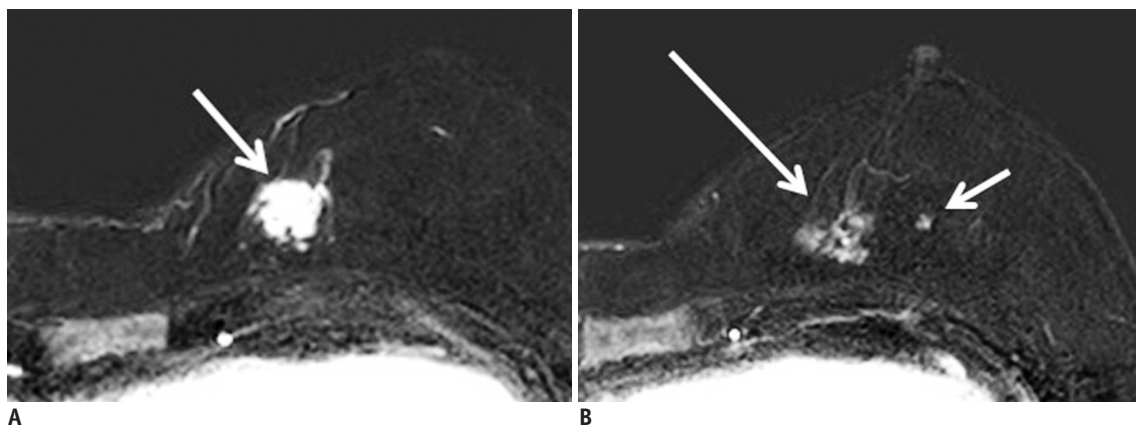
71-year-old female with invasive lobular carcinoma at left upper breast. A, B. Preoperative axial early contrast-enhanced T1-weighted subtraction MR images show malignant mass at left upper medial breast (arrow in A) with adjacent suspicious non-mass enhancement (long arrow in B) and additionally detected suspicious focus at left subareolar breast (short arrow in B). At breast-conserving surgery, positive resection margin was confirmed on intraoperative frozen sectional analysis and additional local excision was performed immediately.
